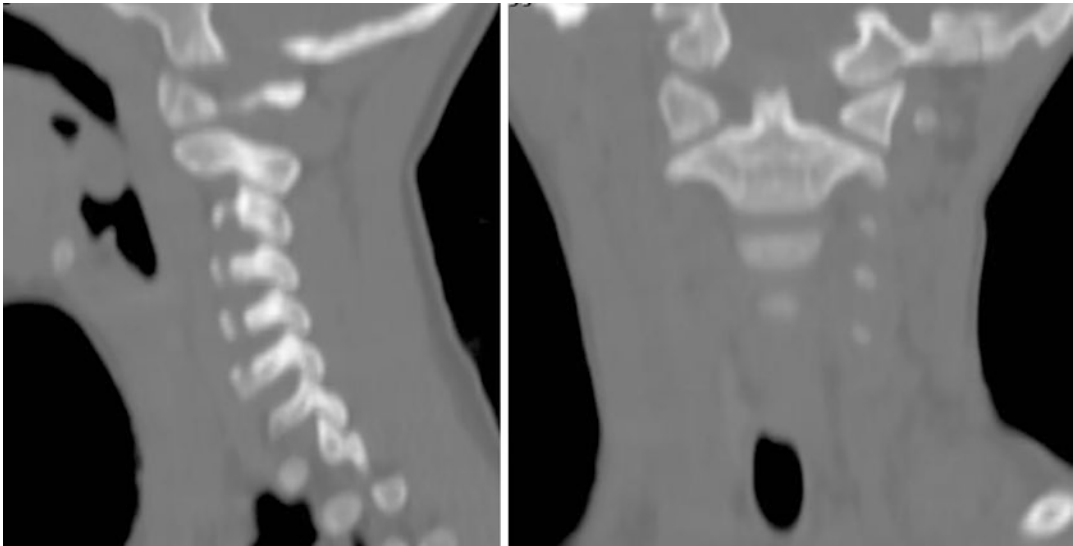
Sagittal and coronal CT reformats showing a widened occipital condyle to atlas distance
